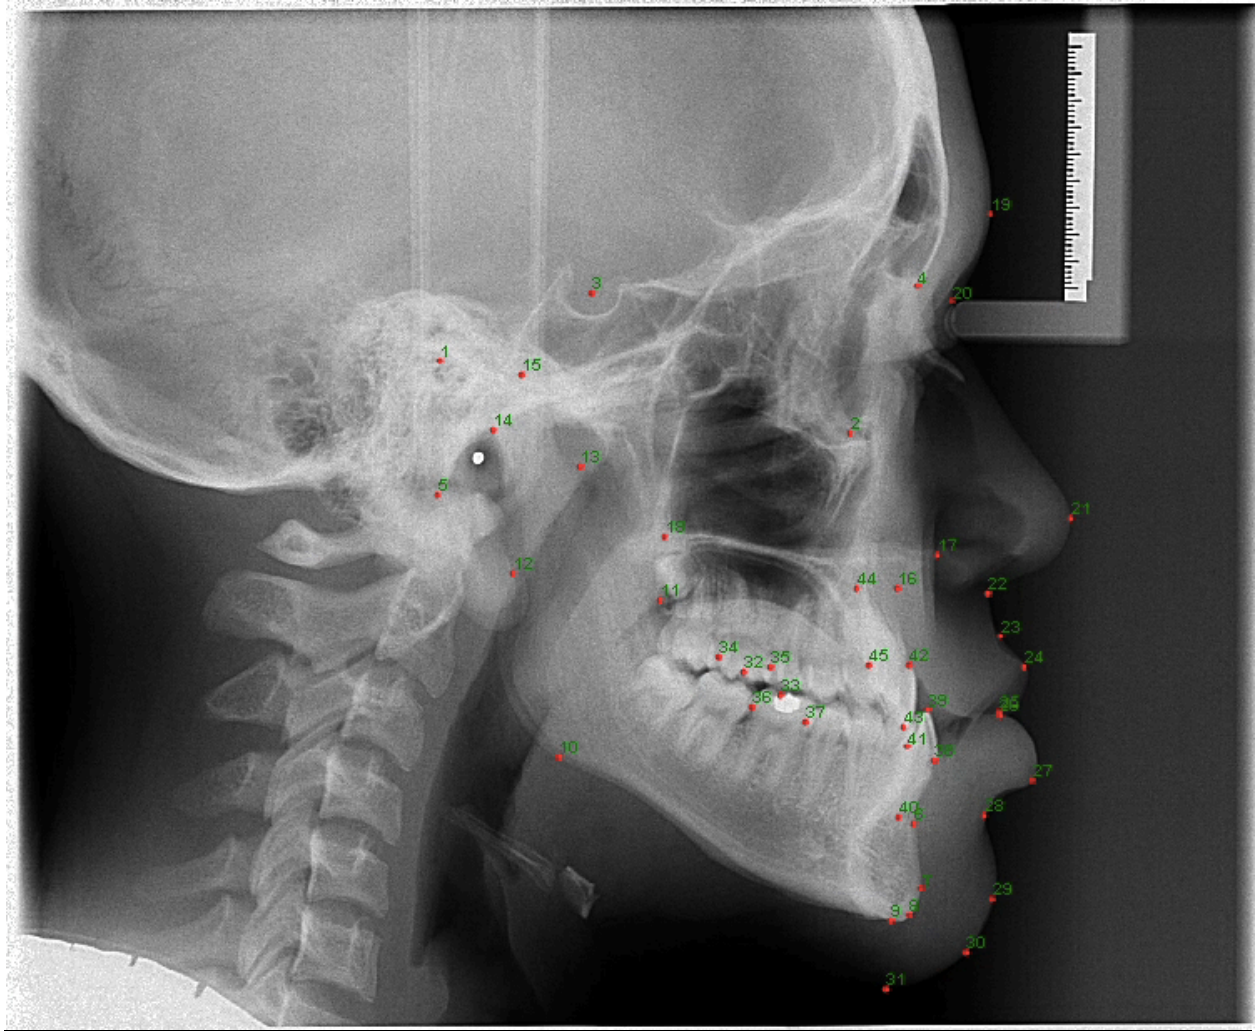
Sample lateral cephalometric radiograph with selected digital landmarks
